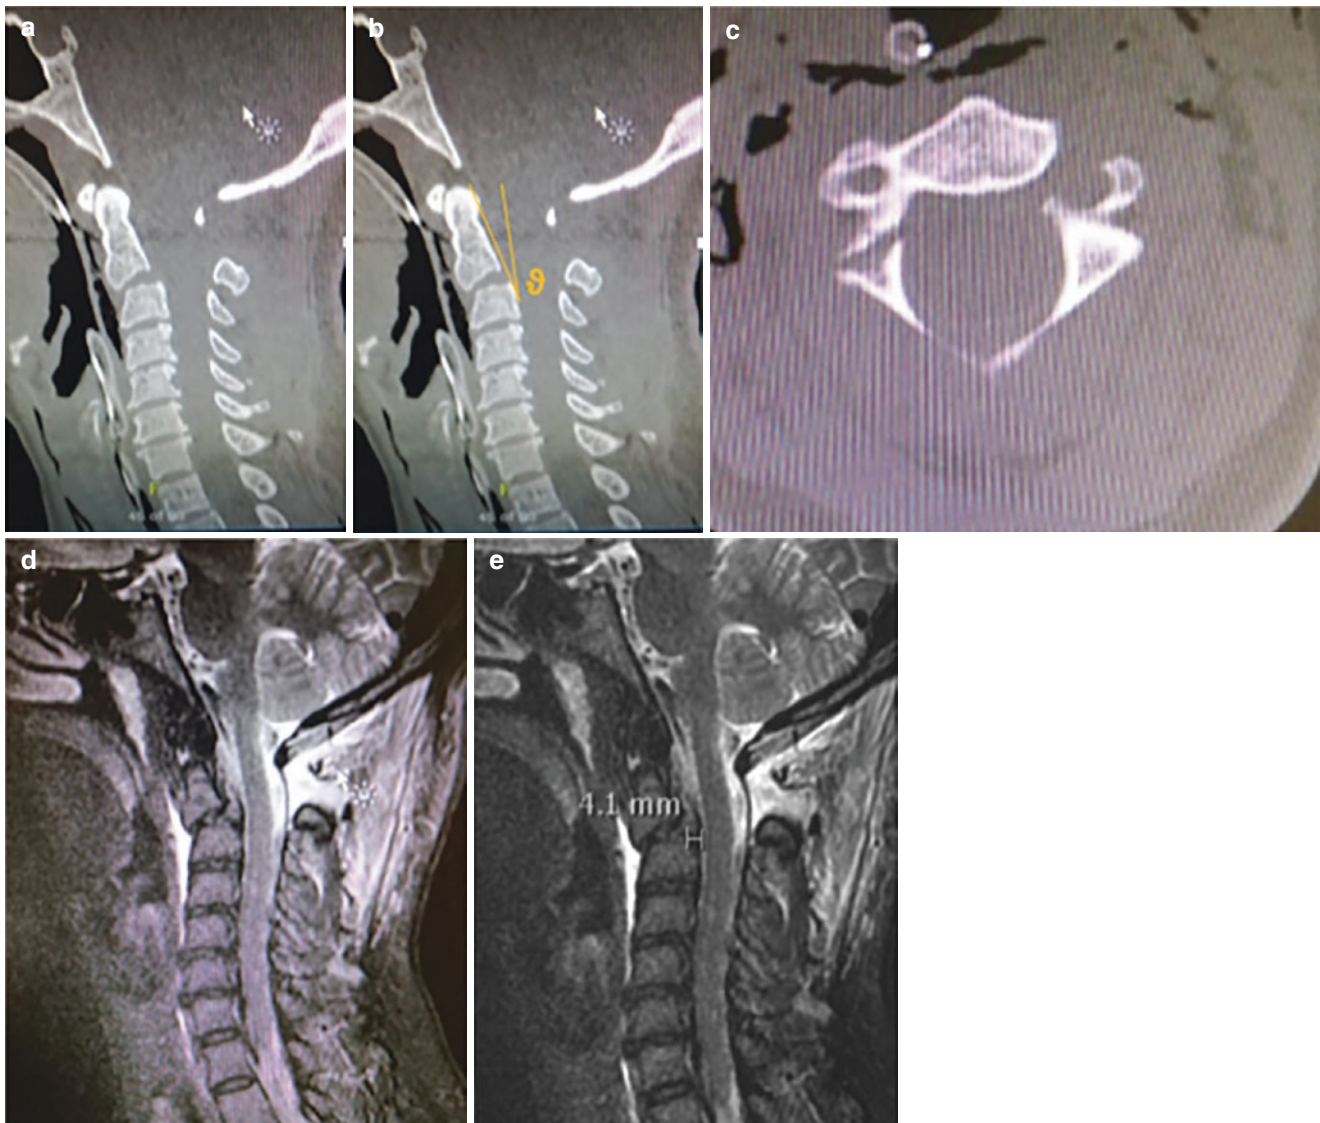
(a) Preoperative sagittal CT cervical spine shows a type II hangman's fracture with severe angulation ($\theta > 11^\circ$ as shown in b) and (b) the displacement of C2 on C3; (c) axial CT scan clearly shows a C2 pars interarticularis fracture; (d and e) the preoperative sagittal T2-weighted
